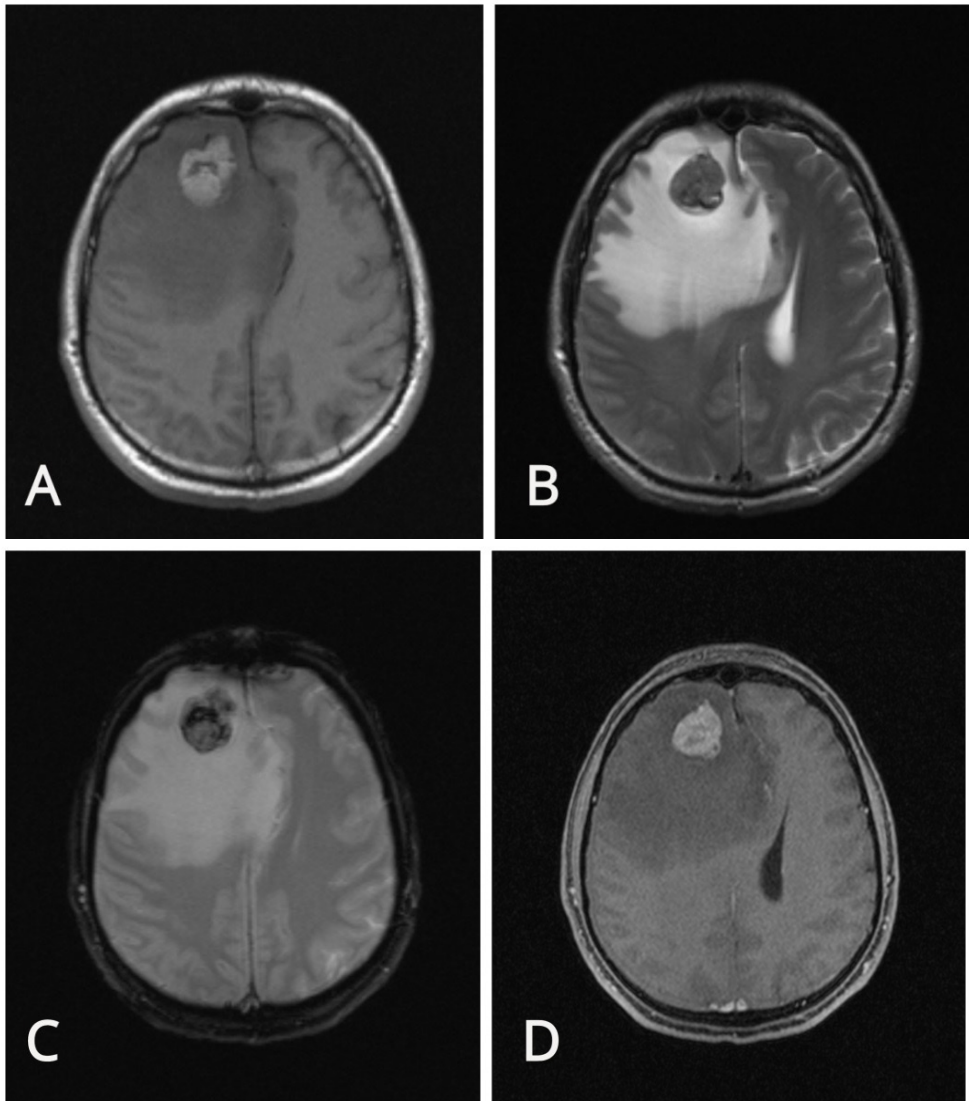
Preoperative brain MRI images, Axial view T1-weighted image (T1WI). (A) Axial view, T2WI. (B) ,) Axial view, T2 FLAIR weighted sequence (C) Axial view, contrast-enhanced T1WI (D). The right frontal lobe lesion appeared hyperdense on brain computed tomography (CT), short signal on T1-weighted magnetic resonance images (T1WI) and long signal on T2-weighted magnetic resonance images (T2WI) with heterogenic signal on T2 FLAIR weighted sequence
